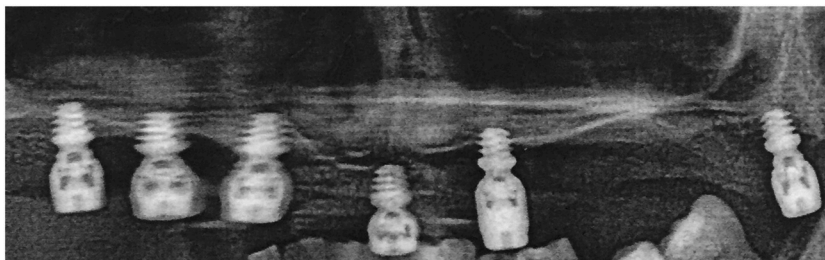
Post-operative Orthopantomography (OPG) showing the six 4-mm-supershort implants in place.
